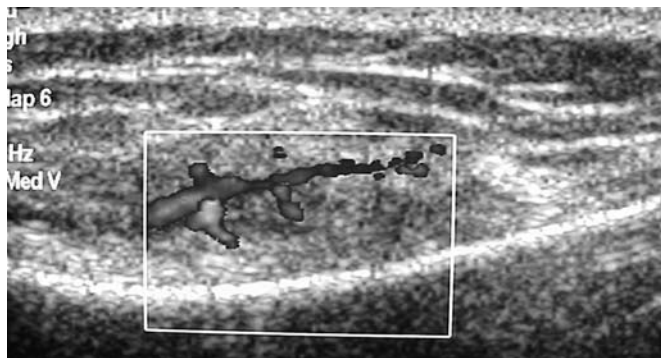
Coronal plane colour Doppler ultrasound of the pes anserinus tendon insertion. The increased colour flow in and around the tendon indicates a paratendinitis.
